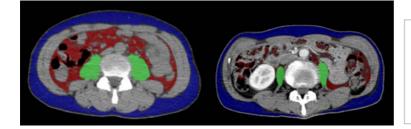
Evaluation of muscle mass by abdominal CT.
